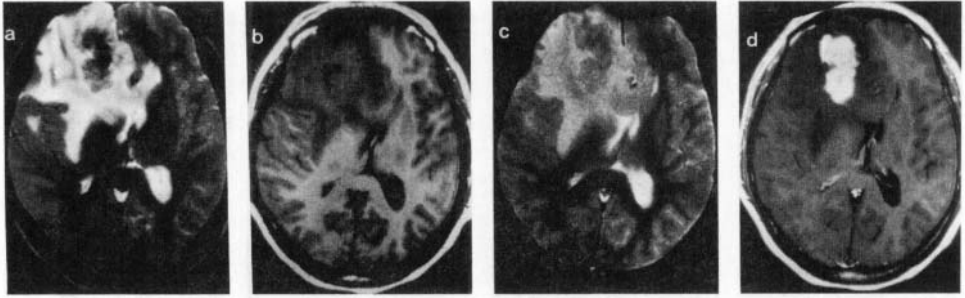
CNS aspergillosis. A large mixed-intensity lesion with predominantly central hypointensity seen in the right frontal region (a) with perifocal edema and mass effect on T2-weighted image. T1-weighted image (b) shows no hemorrhage and GRE image (c) does not reveal any T2 \* effect. Postcontrast T1-weighted image (d) shows intense enhancement of the lesion.
